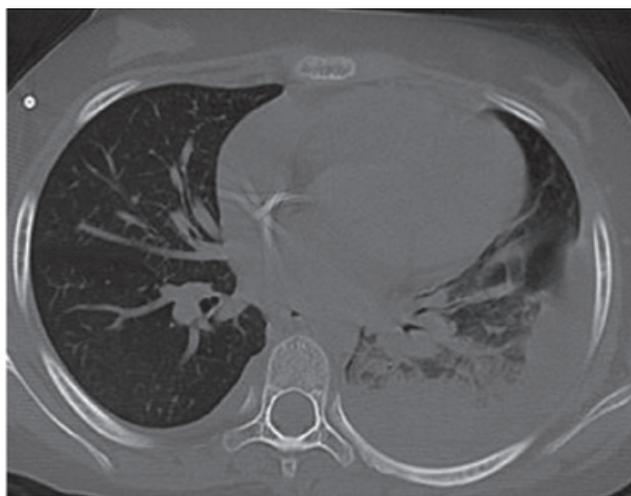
Thorax computed tomography showed a pneumonic consolidation and pleural effusion in the left lower pulmonary lobe
